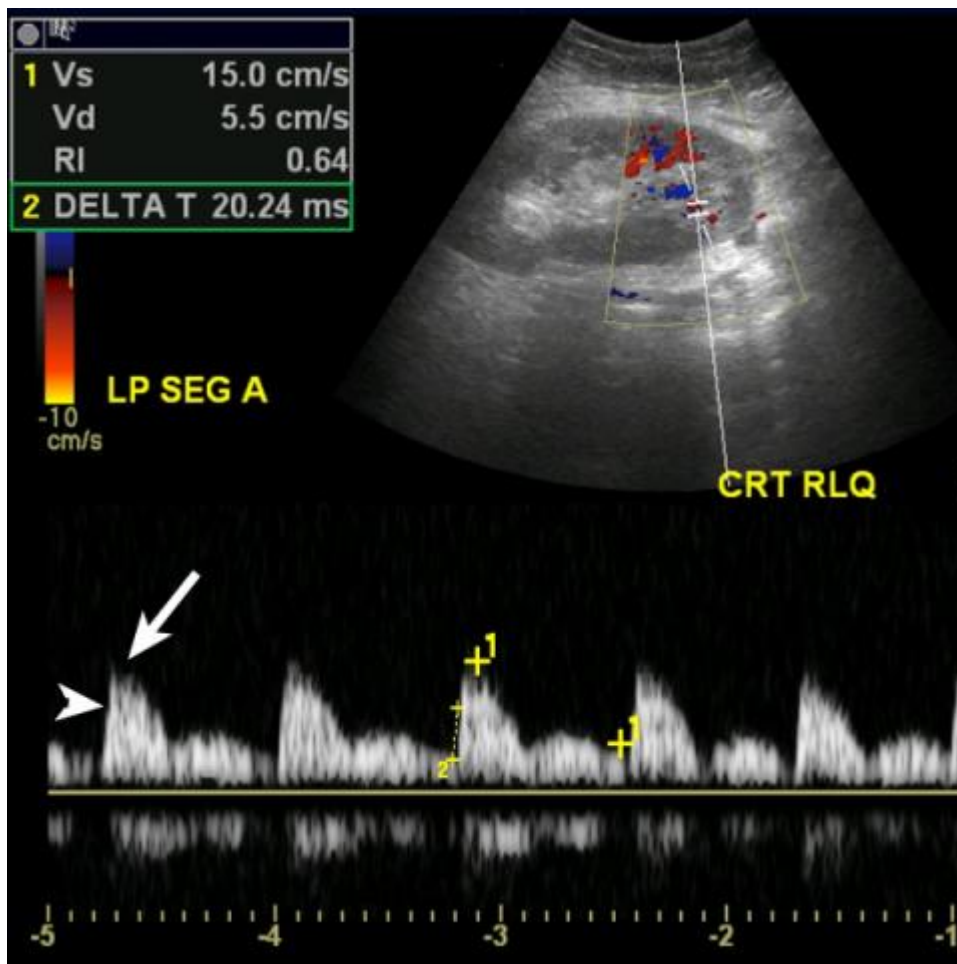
Normal segmental arterial waveform. Spectral Doppler image shows a brisk systolic upstroke (arrowhead), normal systolic notch (arrow) and normal resistive index.
